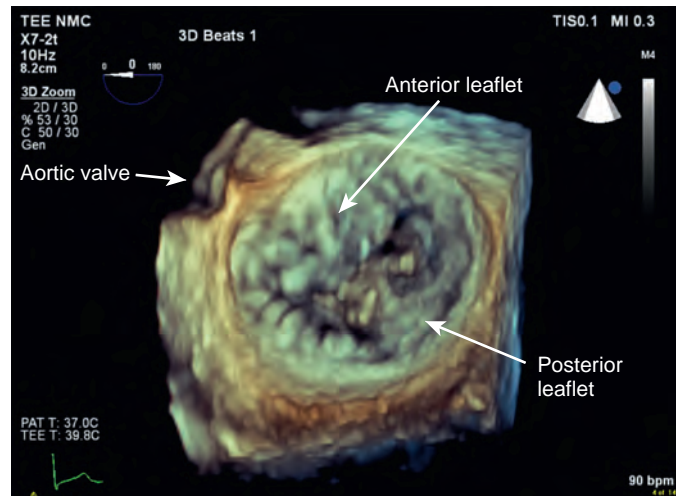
Three-dimensional transesophageal echocardiographic image of the mitral valve displayed in the surgeon's view.
